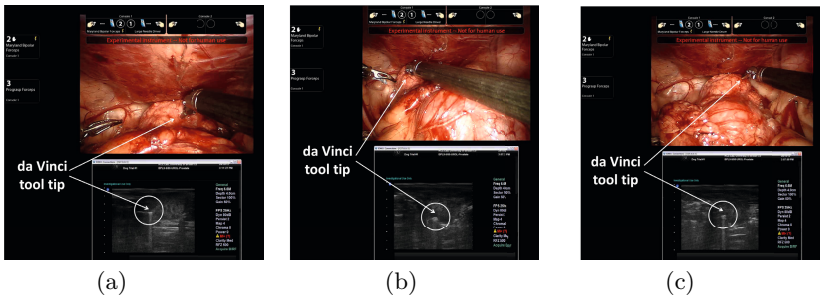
TilePro images inside the surgeon console while the automatic tool tracking is activated. The da Vinci instrument tip is visible in both camera and ultrasound images.
